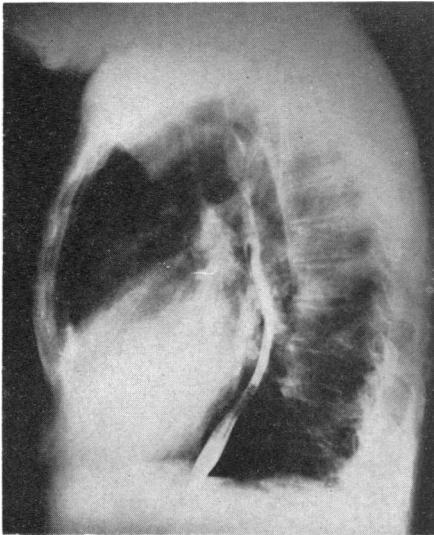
Lateral radiograph of chest, showing enlargement of left atrium.
